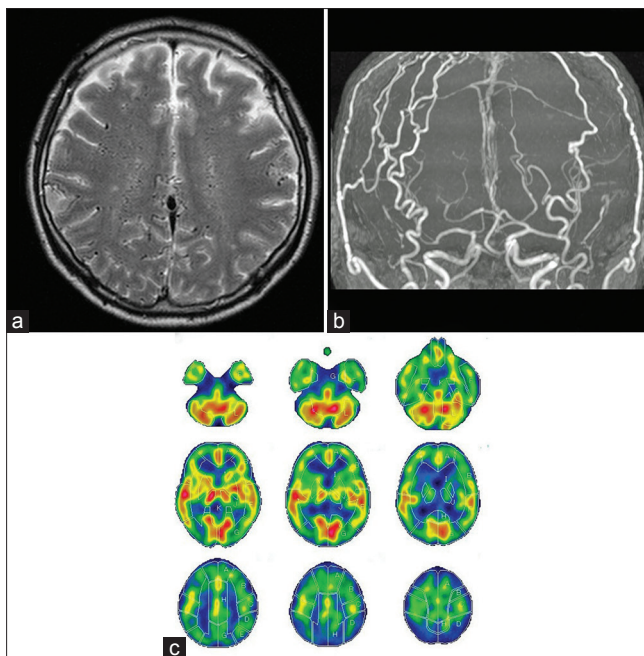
(a) Preoperative T2-weighted magnetic resonance image revealing multiple aberrant medullary veins. (b) Magnetic resonance angiography revealing expanded bilateral occipital arteries and superficial. (c) Iodine-123-N-isopropyl-p-iodoamphetamine single-photon emission computed tomography revealing hypoperfusion of bilateral vertex sides of the frontal, parietal, and occipital lobules
